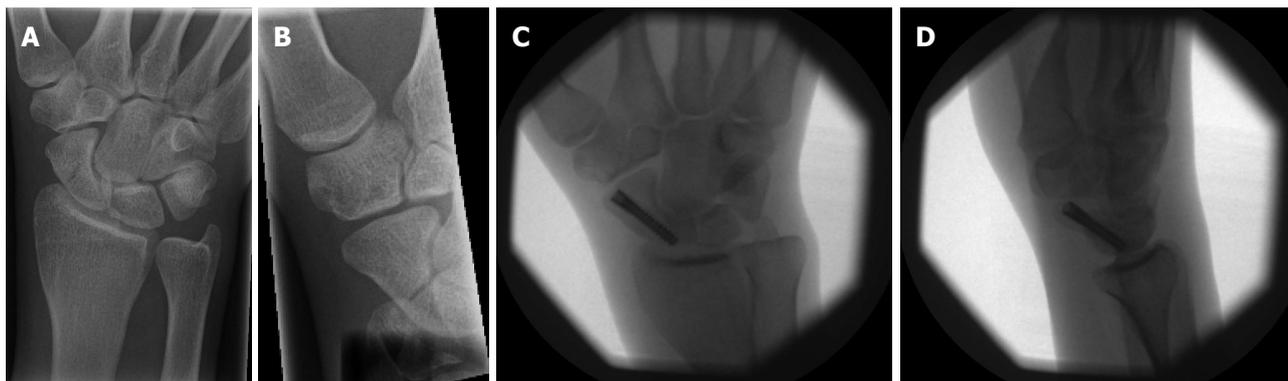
The management of an undisplaced scaphoid waist fracture. A, B: Pre-operative postero-anterior and 45-degree oblique radiographs; C: Intra-operative antero-posterior radiograph; D: Intra-operative lateral radiograph.
